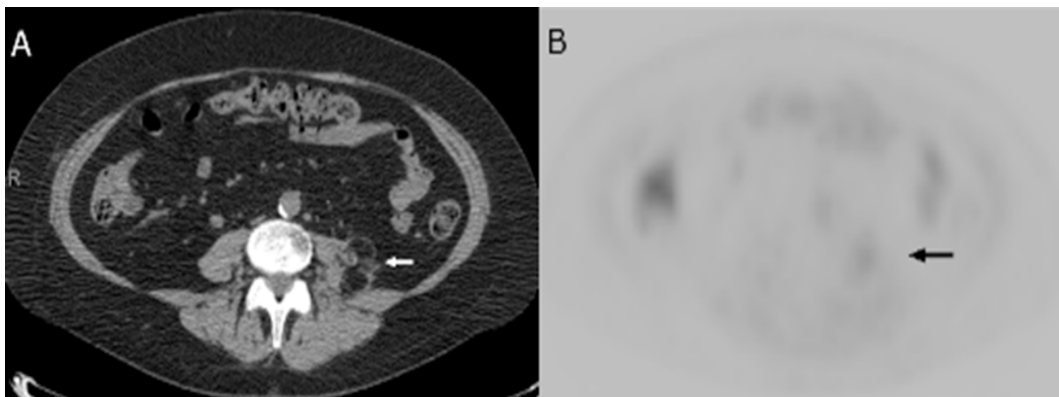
Follow-up: A. Two-year axial CT follow-up image demonstrates a resorbing ablation zone (white arrow) without evidence of recurrent disease. B. Two-year PET axial images demonstrate no significant hyper metabolism in the ablation zone (black arrow) of previous left retroperitoneal mass. Faint metabolism on the medial margin is likely physiologic or related to granulation tissue.
